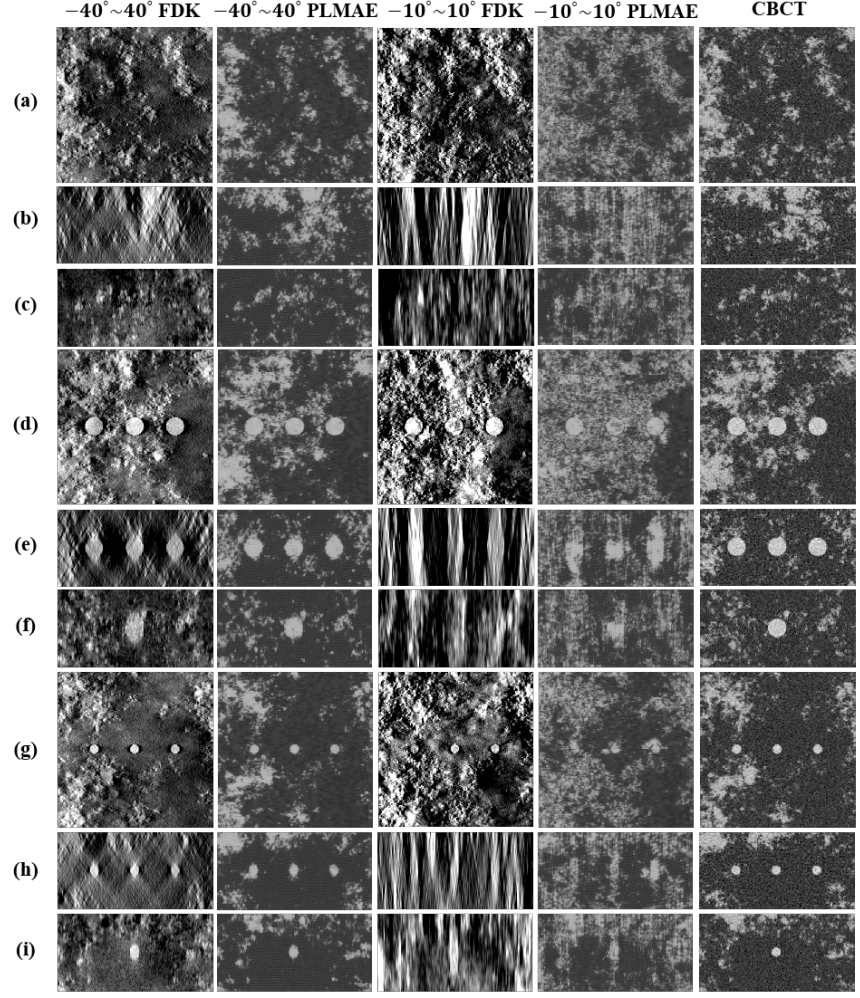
Results with different data acquisition angle. Comparison of DBT images reconstructed by FDK over -40° to 40° and -10° to 10° data acquisition angles with deblurred images by the proposed method. CBCT images are shown as a reference. Images without mass lesion for (a) axial, (b) coronal, and (c) sagittal planes; images containing 4 mm lesions for (d) axial, (e) coronal, and (f) sagittal planes, and images containing 2 mm lesions for (g) axial, (h) coronal, and (i) sagittal planes. The display window is $[0.03 \ 0.10]$ in cm^{-1} .
